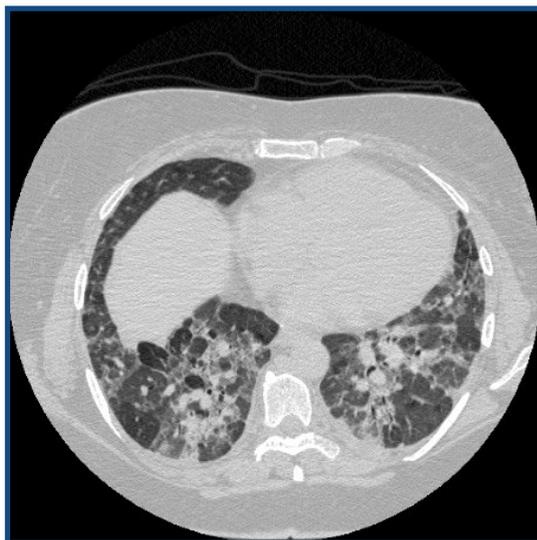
CT showing pulmonary fibrosis with reticular linear shadows, honeycombing and traction bronchiectasis.
